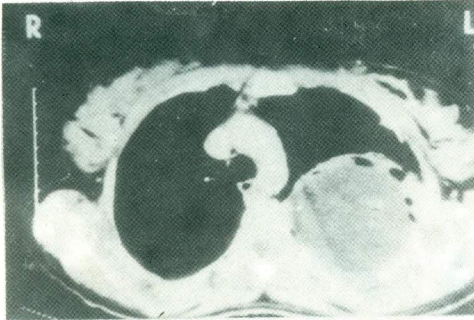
Chest CT of the same patient showing a large cyst with a small amount of perivesical air ("moon sign"- "crescent sign"- "meniscus sign") denoting impending rupture.
